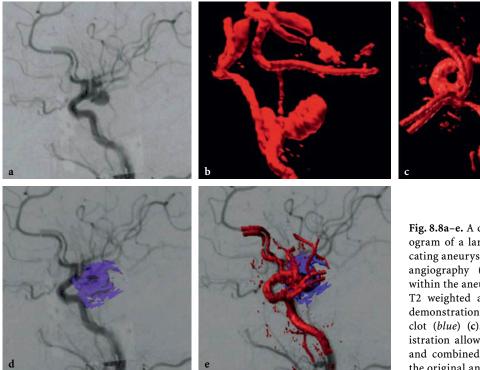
A digital subtraction angiogram of a large posterior communicating aneurysm (a). Time of flight MR angiography (b) demonstrates flow within the aneurysm. Data fusion with T2 weighted anatomical MRI allows demonstration of intra-aneurysmal clot (blue) (c). Fiducial-based coregistration allows fusion of the clot (d) and combined MRI data set (e) with the original angiogram
